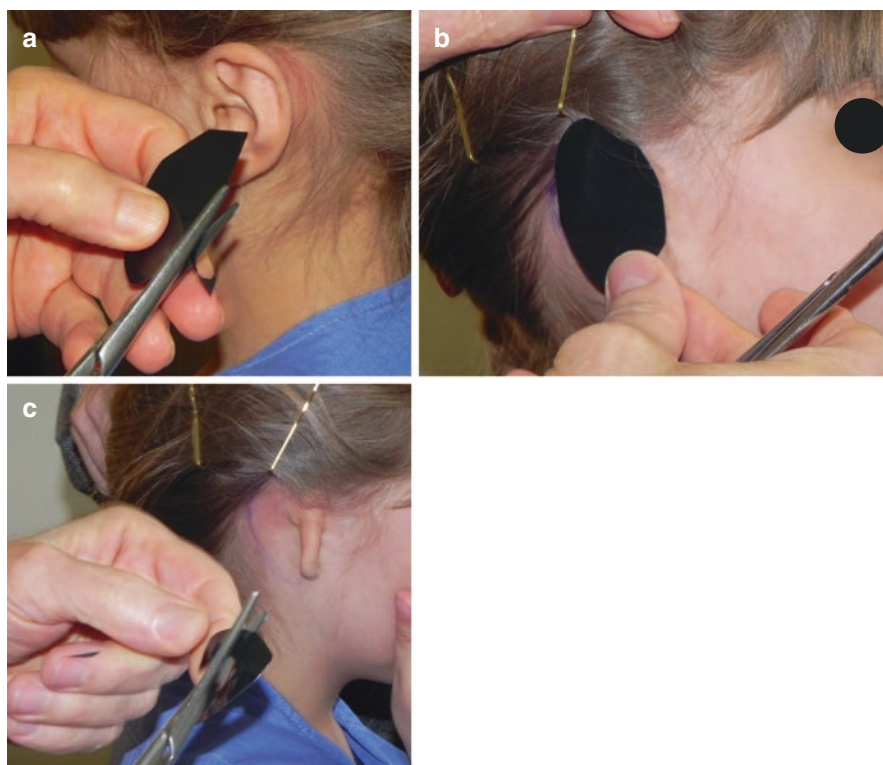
Surgical planning to model the future auricular skeleton before ear reconstruction. Photo (a) the opposite side is taken as reference and prepared in an X-ray film; (b) the model is placed on the deformities to evaluate the size and shape of the future ear; (c) creation of the anatomical details of the model is made with a scissor with patient awake during consultation at the clinic
